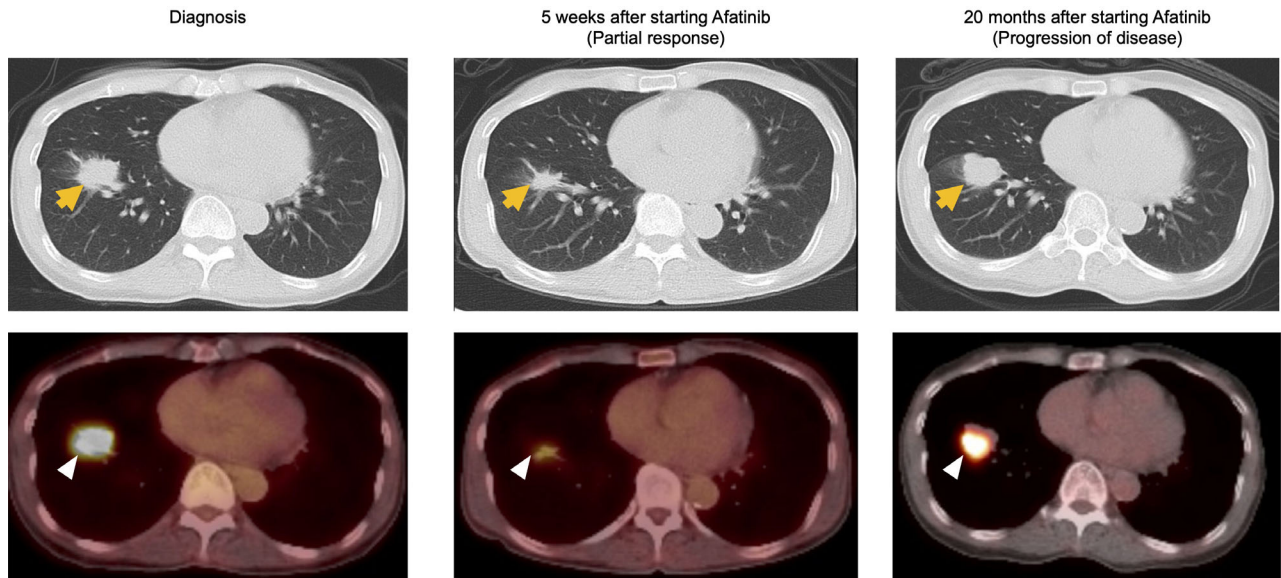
Radiographic findings from diagnosis, and response-assessment at 5 weeks and 20 months after initiation of pulse dose afatinib. Yellow arrows represent lung findings on computed tomography chest and white arrowheads represent fluorodeoxyglucose-avid areas on positron emission tomography scan.
